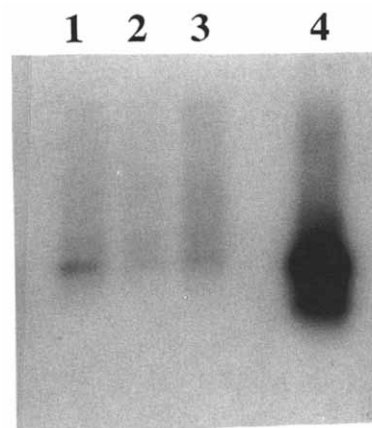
Autoradiogram after hybridization, with CT-specific probe, of a Southern blot with PCR products amplified with specific CT mRNA primers. (Lanes 1-3) Control tissues, each sample represents 1/4 of the starting material; (lane 4) MTC tissue, 1/40 of the PCR reaction was analysed.
